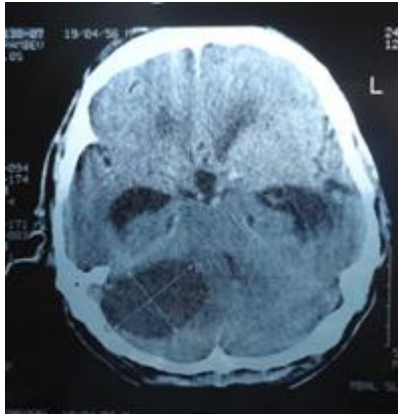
CT image of acoustic neuroma with hydrocephalus
